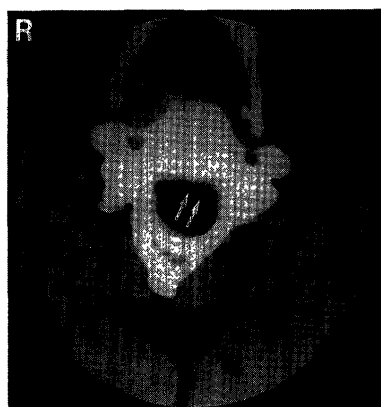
CT myelogram at the C2 level, showing an intradural low-density mass and the displaced cervical cord (arrows).
